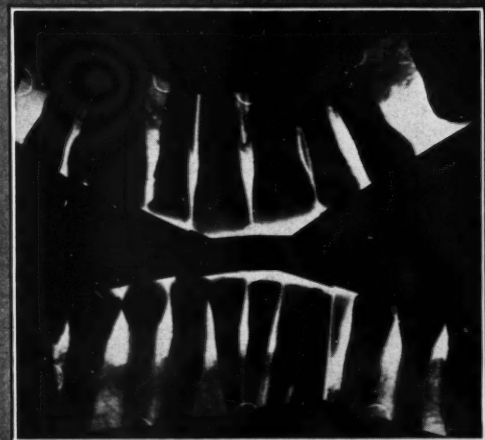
The lower jaw shows the appearance of the gums five weeks after removal of the pack. The upper jaw ten days after removal of the pack. The roentgenograms give an idea of the established nature of the disease in this case in which the patient was very young with exceptionally good mouth hygiene.
